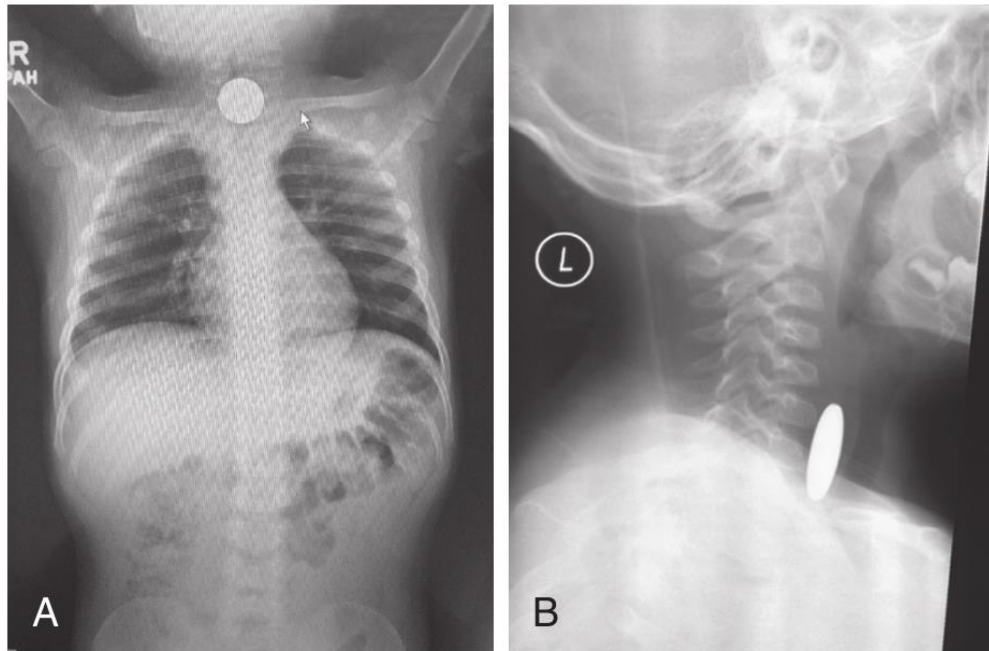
A posteroanterior radiograph demonstrates a coin lodged in the aerodigestive tract and oriented in the coronal plane, indicating it is likely in the esophagus. B, A lateral radiograph confirms the location of the coin to be posterior to the trachea in the esophagus. (Courtesy Andrew Murr, MD.)
